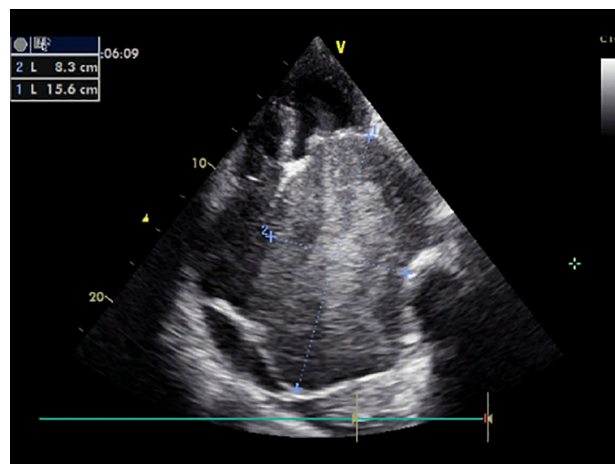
Transthoracic echocardiogram (apical 4-chamber view) shows severe left atrial enlargement and flow of spontaneous echo contrast through the mitral valve.
